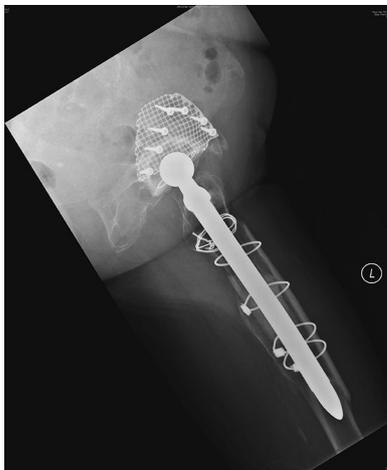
Four years postoperative lateral radiograph showing a horizontal radiolucent line at the anterior femoral cortex at the distal tip of the femoral stem.
